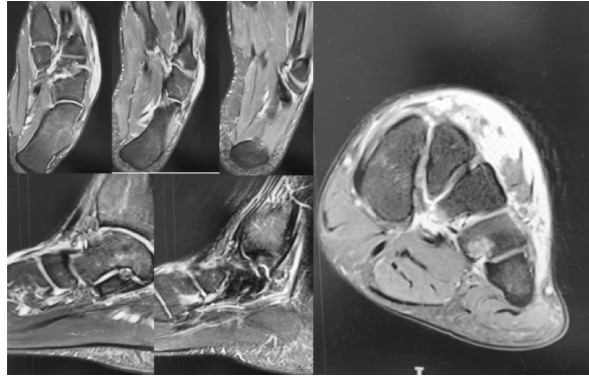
MRI, multiplanar images in T1 and T2 sequence and proton density with fat suppression. Small fracture of the cuboid bone of the left foot reaching the articular surface, without misalignment, with bone edema and fracture at the base of the fourth metatarsal. Edema and irregularity of the muscle fibers of the extensor digitorum brevis of the first toe and extensor digitorum brevis of the fingers.
